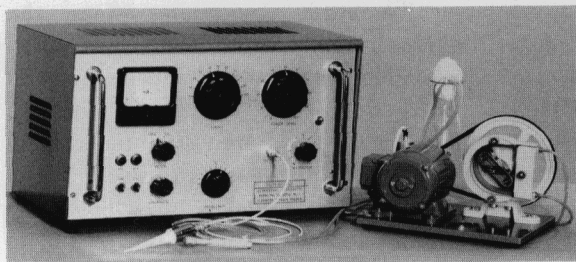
The Uppsala ultrasonic apparatus.
